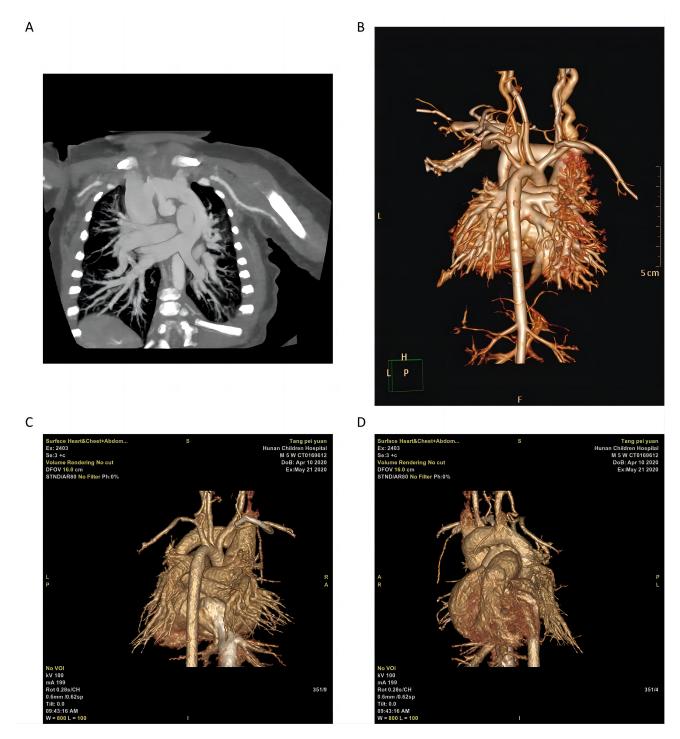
Detailed CTA 3D reconstruction of pulmonary veins. (A) The Maximum Intensity Projection (MIP) demonstrates the confluence of the four pulmonary veins, which subsequently drain into the brachiocephalic veins via vertical veins, and then return to the right atrium through the dilated superior vena cava. (B) The Volume Rendering (VR) image reveals the convergence of the four pulmonary veins into a common lumen. (C) VR image displays the aortic arch and its branches, as well as the left and right pulmonary arteries, with the inferior right pulmonary vein also visible. (D) VR image shows the pulmonary artery outlet, aortic arch, and its branches. 3D, three dimensiona.
